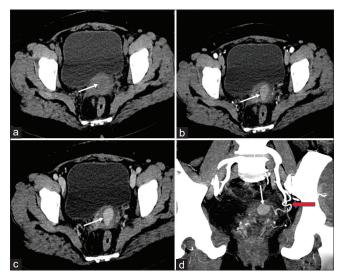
Axial noncontrast (a), Arterial (b), and venous phase (c) images show a saccular contrast-filled outpouching (White arrow is marked to highlight the site of pathology in a multiphasic CT pelvis.) in the vaginal vault region with no change in shape and size in the venous phase, suggestive of an arterial pseudoaneurysm; Coronal MIP (d) Image shows the pseudoaneurysm, arising from the left uterine artery (red arrow d). MIP: Maximum intensity projection
